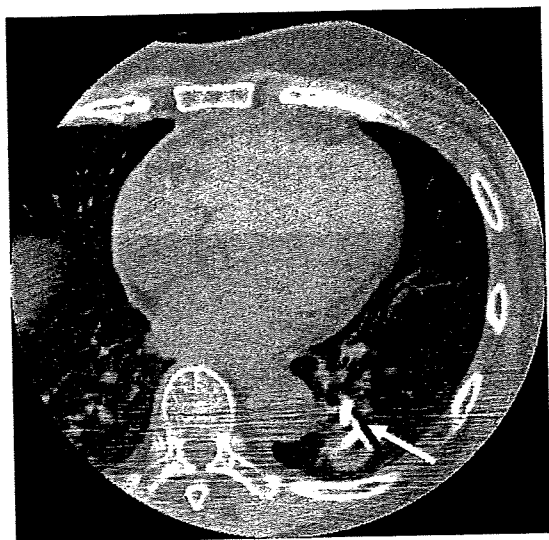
CT scan showing the forceps advanced towards the lesion during CT-guided transbronchial lung biopsy.
